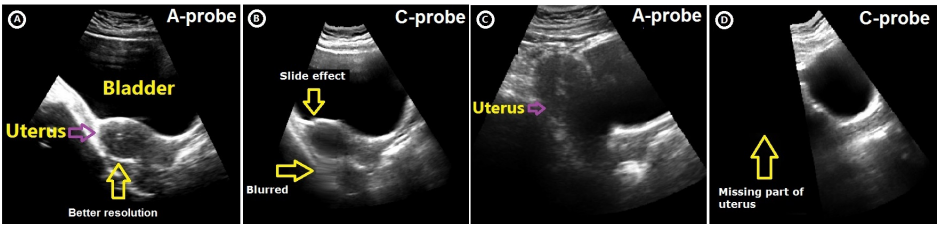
Transabdominal ultrasound imaging; (A) Using the C-probe, and (B) using the A-probe.
